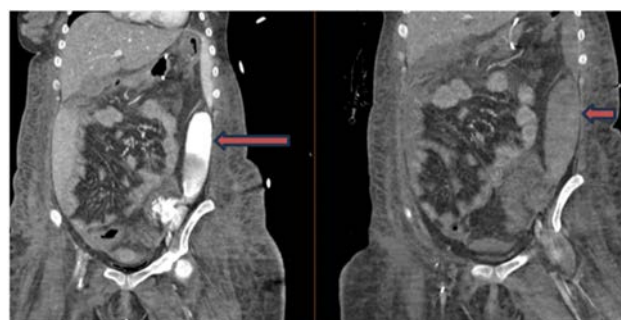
Displays CT Scan Images from Two Different Days, Providing a Comparison Between Images with and without Contrast to Distinguish Between Urinoma and Suspected Hematoma
